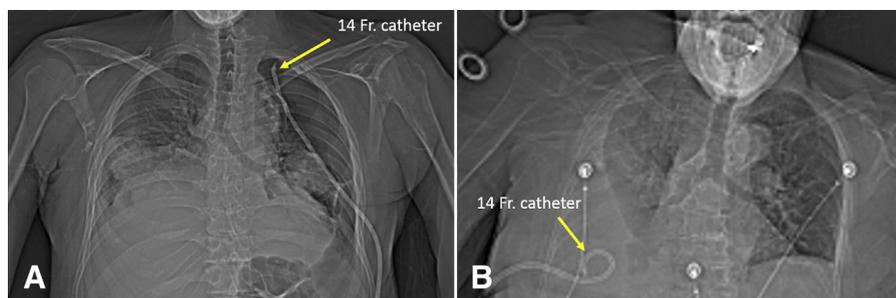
(A) Computed tomography scout image from patient 1 shows a straight catheter tip, an indication that the catheter obturator remains in place. (B) A different patient, with the 14-Fr catheter correctly inserted without the catheter obturator in place, shows the expected curled “pigtail” shape.
